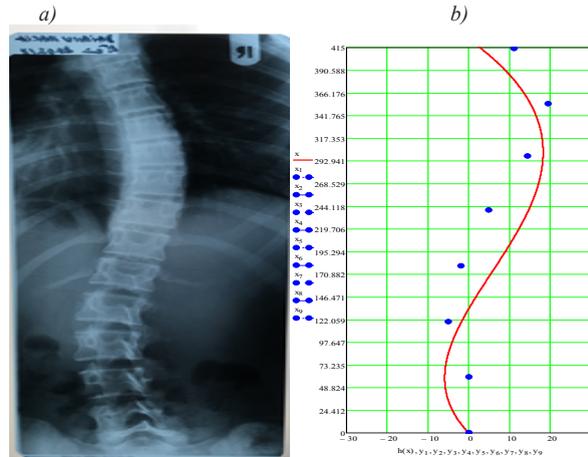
(a) The X-ray of the study column; (b) The graphical model of the column calculated using the 5th degree polynomial
